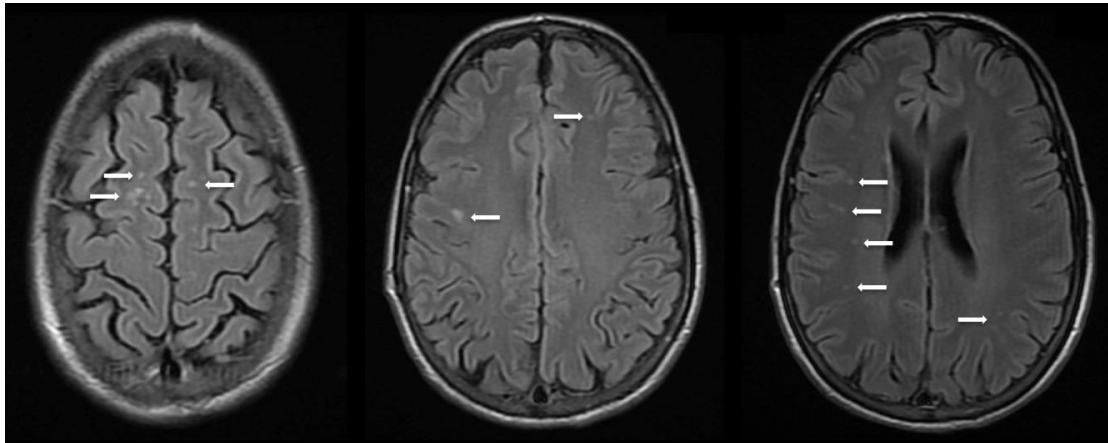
MRI brain sections demonstrating non specific white matter lesions (white arrows).
